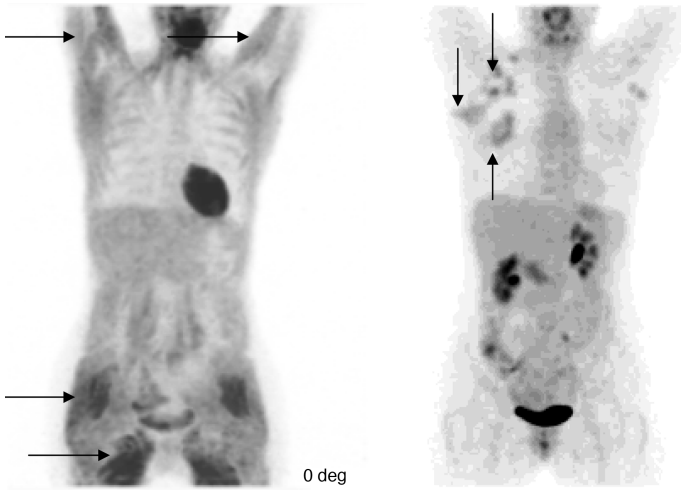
High serum glucose causes false-negative FDG PET results. At the time of the PET scan on the left, the patient's serum glucose was 225 mg/dL. There is excessive gluteal and other muscle uptake (*horizontal arrows*). The scan on the right, performed on the same patient within 2 days and with serum glucose at 120 mg/dL, shows no excessive muscle uptake and evident tumor uptake (not seen on the scan on the left) in the right breast and axilla (*vertical arrows*). (Case provided by Alan Waxman, MD)
